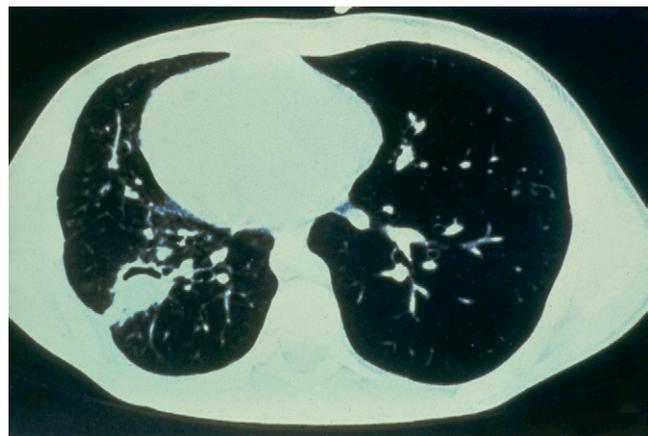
CT scan of a bone marrow transplant recipient showing a large cavitating lesion.
